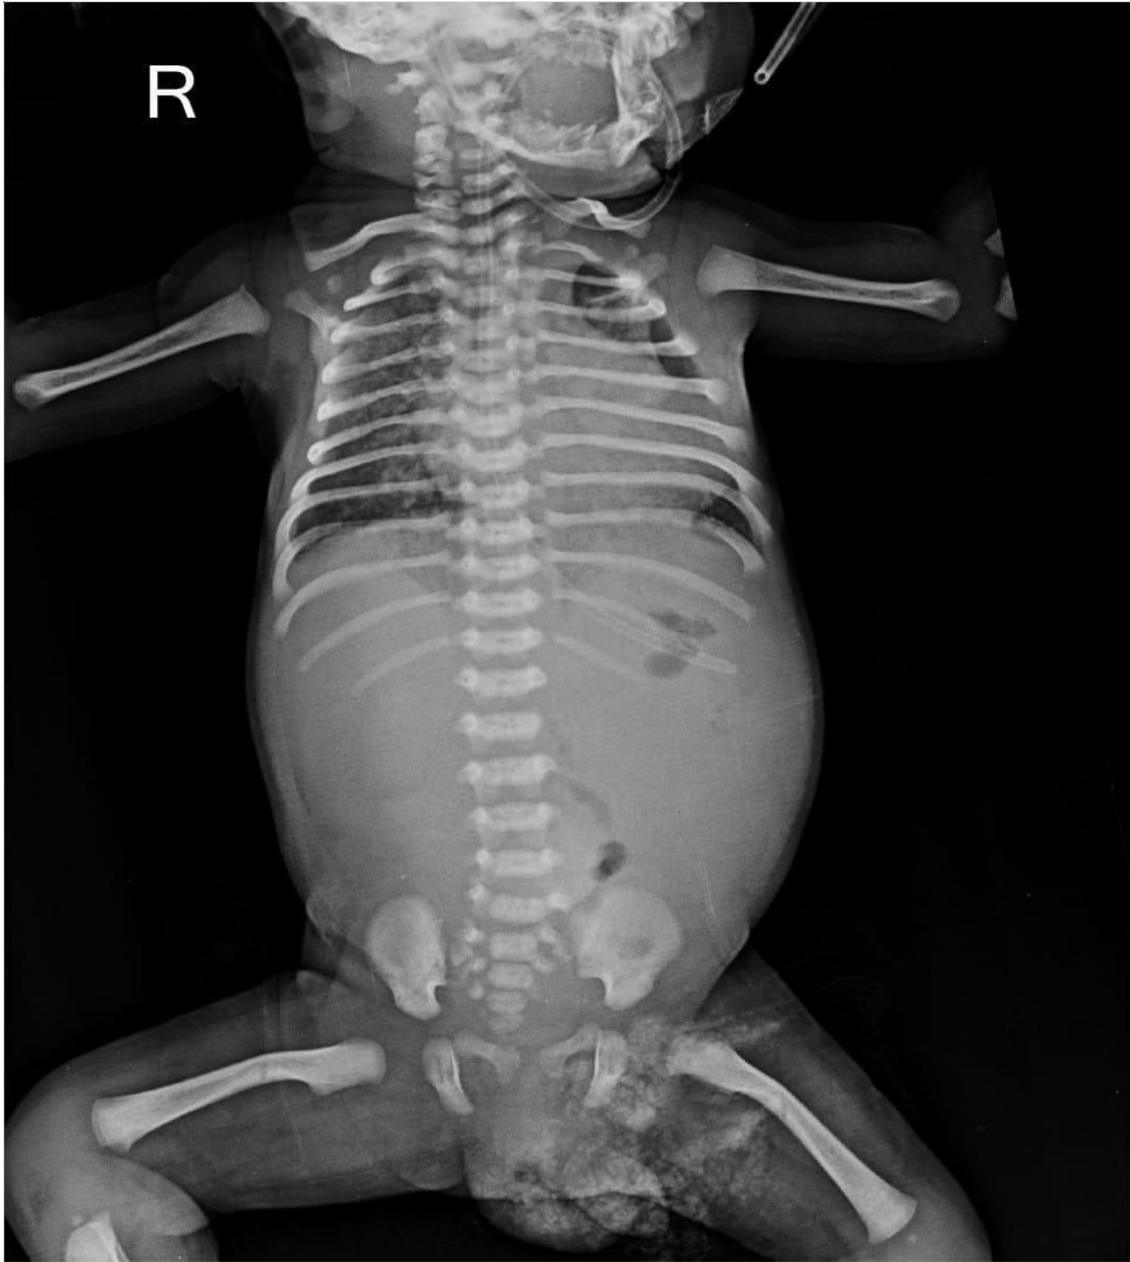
X-Ray Chest AP view
